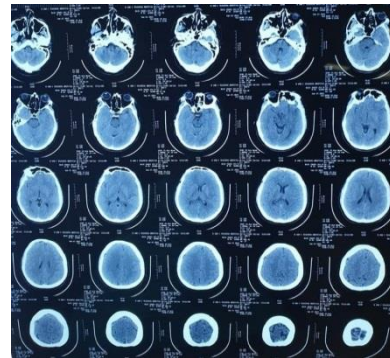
Computed Tomography 8 hours post procedure.
